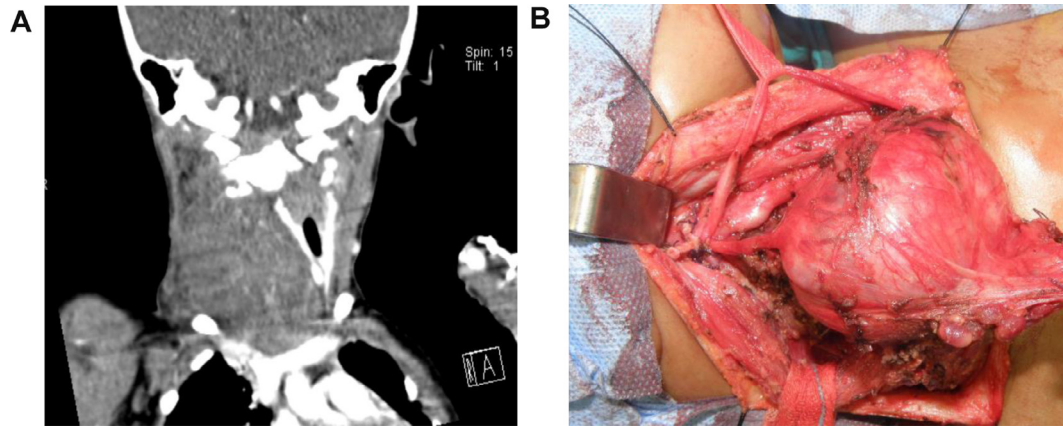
(A) CT coronal view of cervicothoracic NB. (B) Intraoperative view of cervical approach.
